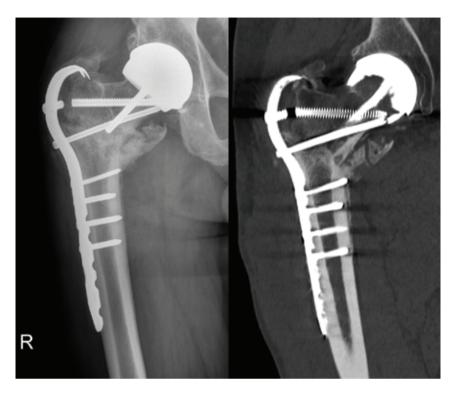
A, B. Initial healing of the fracture shown by x-ray and CT scan imaging at six-month check-up.
